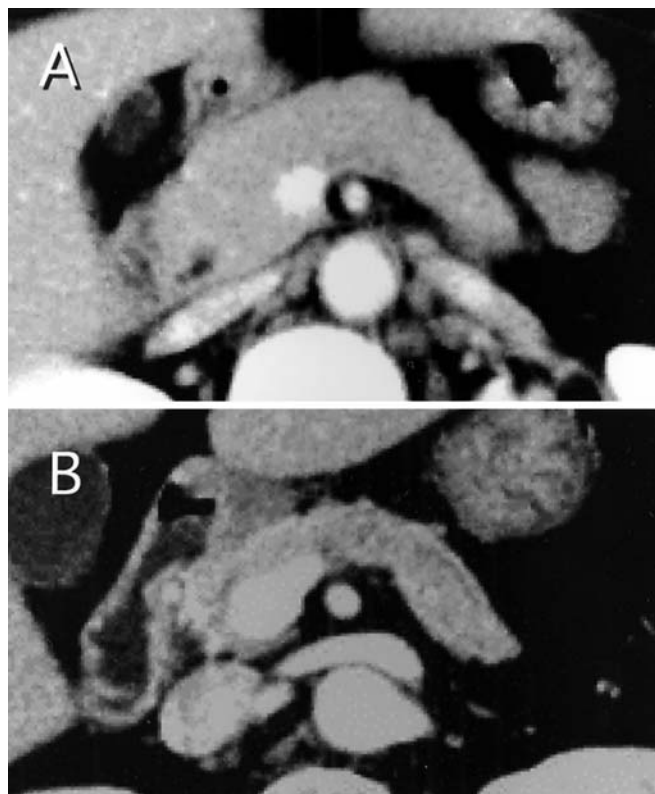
Abdominal computed tomography shows diffuse enlargement of the pancreas but no peripancreatic involvement prior to steroid therapy (A). Three months after steroid therapy, the pancreas has decreased in size and seems atrophic rather than normal (B)
